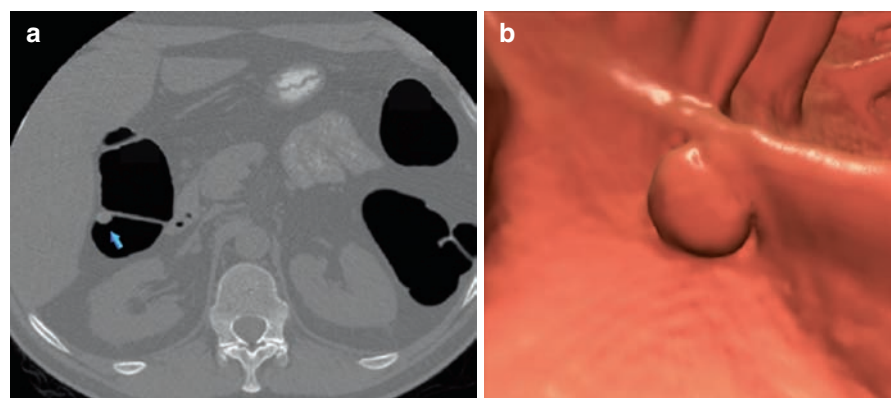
Colonic adenoma: (a) axial CT image and (b) 3D image demonstrate a tubular adenoma with low-grade dysplasia in the transverse/ascending colon
